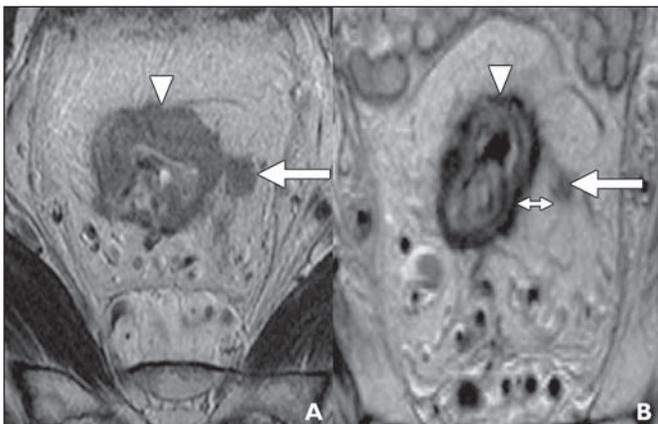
67-year-old man with rectal cancer. A, Baseline axial T2-weighted MR image shows semiannular infiltrating tumor (*arrowhead*). Nodule (*arrow*) of intermediate signal intensity is seen in medium-sized vein at 3-o'clock position. B, Posttreatment axial image shows tumor regression within rectal wall. Fibrotic low-signal-intensity scar (*arrowhead*) is seen between 9- and 4-o'clock positions. Focus of residual disease (*single-headed arrow*) remains in vein at 3-o'clock position. Overall these MR findings show mixed response to treatment; MRI assessment of tumor regression grade is 3. Residual venous disease is 6 mm (*double-headed arrow*) beyond muscularis propria indicating posttreatment T3c stage.
